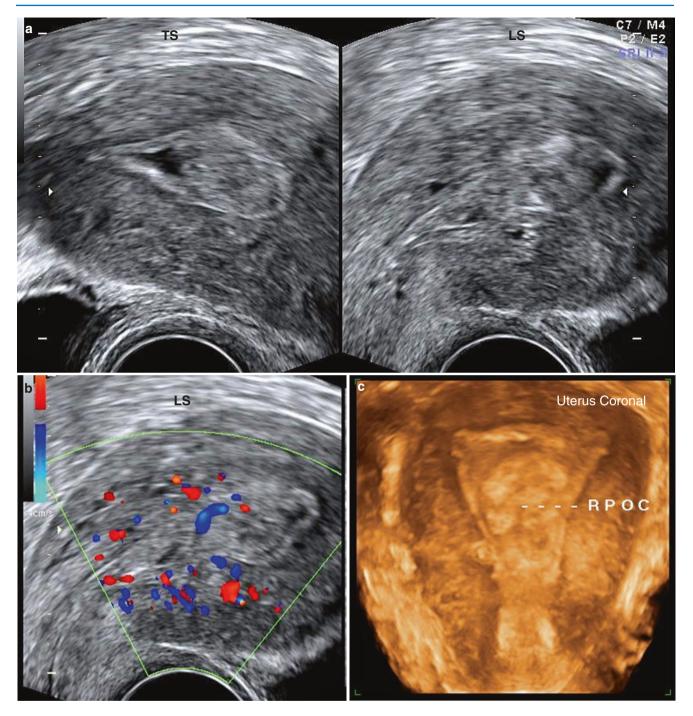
RPOC following missed abortion with bleeding. (a) Hyperechoic, complex mass seen in the endometrial cavity. On TS, it appears completely within the cavity with minimal fluid on one side. On LS, the anterior margins were not well defined because of an anterior wall adenomyoma. (b) RPOC showing flow within, on Doppler, which helps to confirm diagnosis. (c) 3D rendered image showing the complex appearing RPOC within the endometrial cavity
